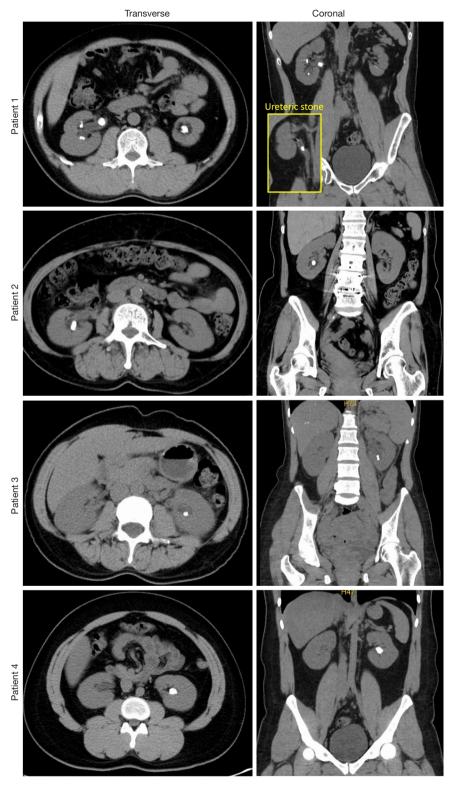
Preoperative computed tomography scans in transverse (left column) and coronal (right column) planes for patients 1 to 4 that have successfully undergone stone removal procedures using the flexible and navigable suction ureteral access sheath. Lower pole stones can be seen. The ureteric stones for patient 1 are included in yellow boxes for reference.
